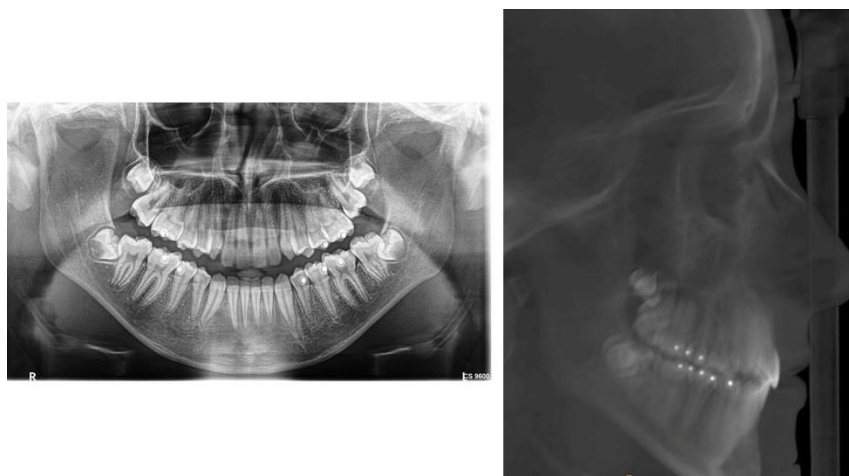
Orthopantomography and Cephalometry at the end of the orthodontic treatment
